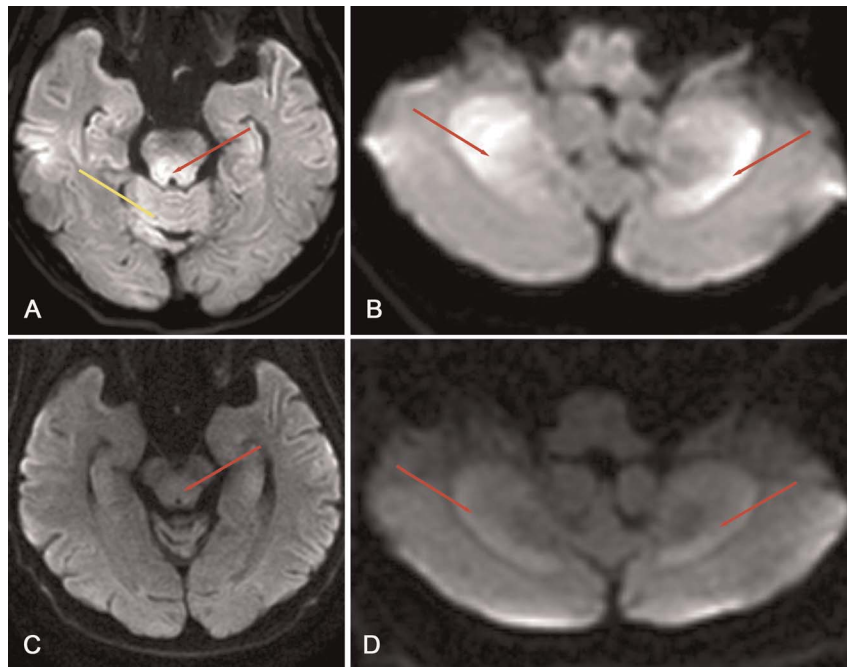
Diffusion-weighted imaging (DWI; $b = 1000$) of a 67-year-old man with toxic encephalopathy due to food poisoning from money tree seeds. (A–B) High-signal DWI at the initial presentation demonstrated symmetric signal hyperintensity surrounding the bilateral cerebellar dentate nucleus (red arrow in Fig. 3B), dorsal medulla oblongata, midbrain aqueduct (red arrow in Fig. 3A), and cerebellar vermis (yellow arrow in Fig. 3A). (C–D) Follow-up DWI after 15 days revealed a reduction in lesion scope (red arrow in Fig. 3C–D) and mostly resolution of the diffusion-restricted areas.
